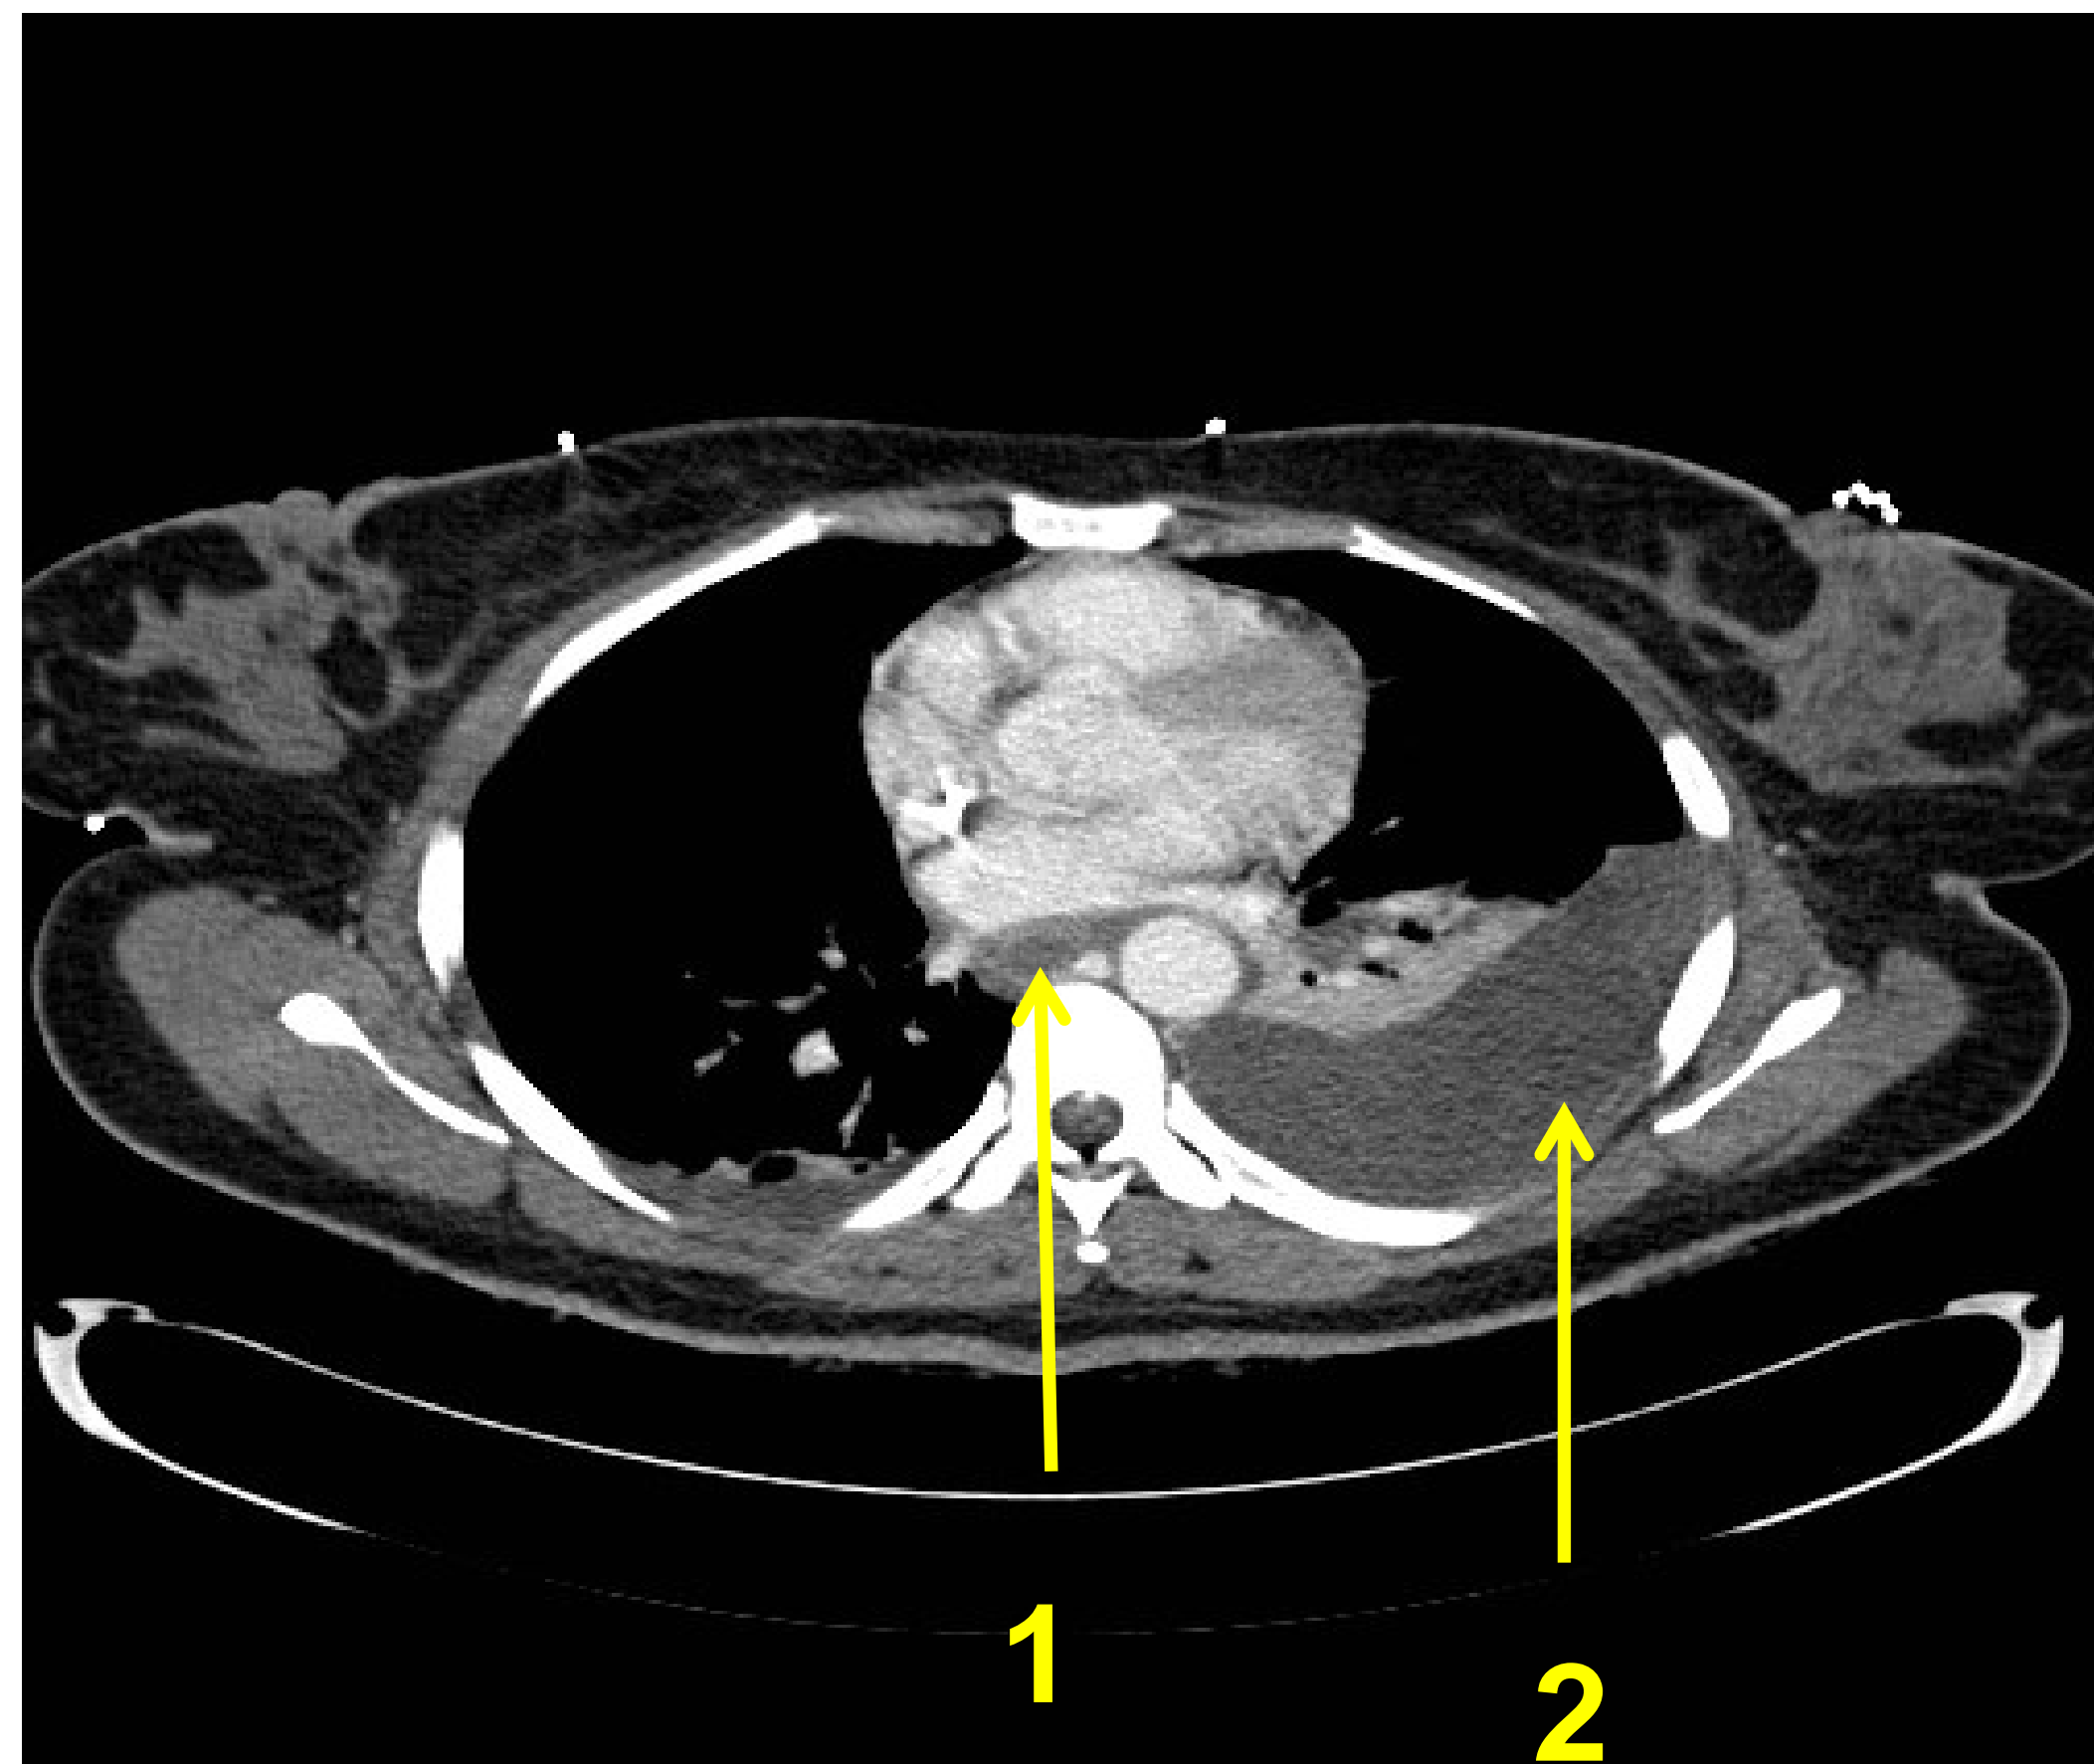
CT cross-section at level of distal thorax
